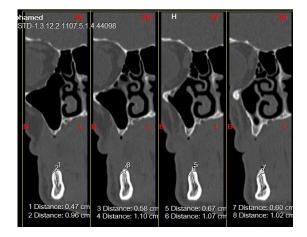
CT dentascan showing the distance of the alveolar crest (linguo – buccal) space
